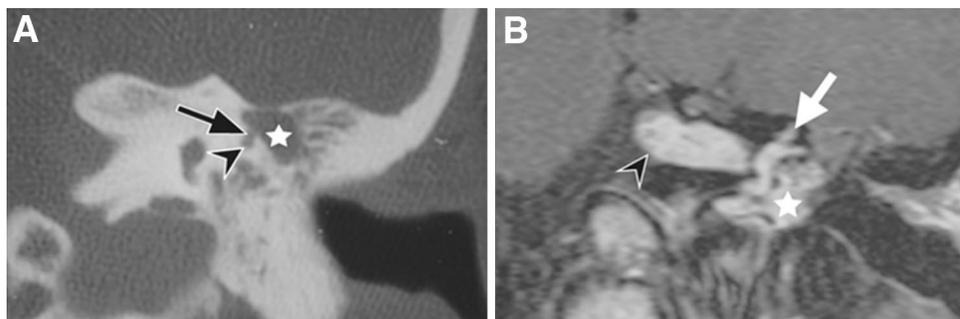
Case 1, pathologically-proven vestibular schwannoma extending towards the middle ear through the inner ear. a Coronal non-enhanced temporal bone multidetector CT showing a hypodense filling of the middle ear cavity (star). A thin hypodensity was also observed (arrow) in the postero-superior portion of the walls of the lateral semicircular canal (arrow head). b Coronal T1-weighted contrast-enhanced spin-echo sequence at 1.5 T, acquired 10 min after
